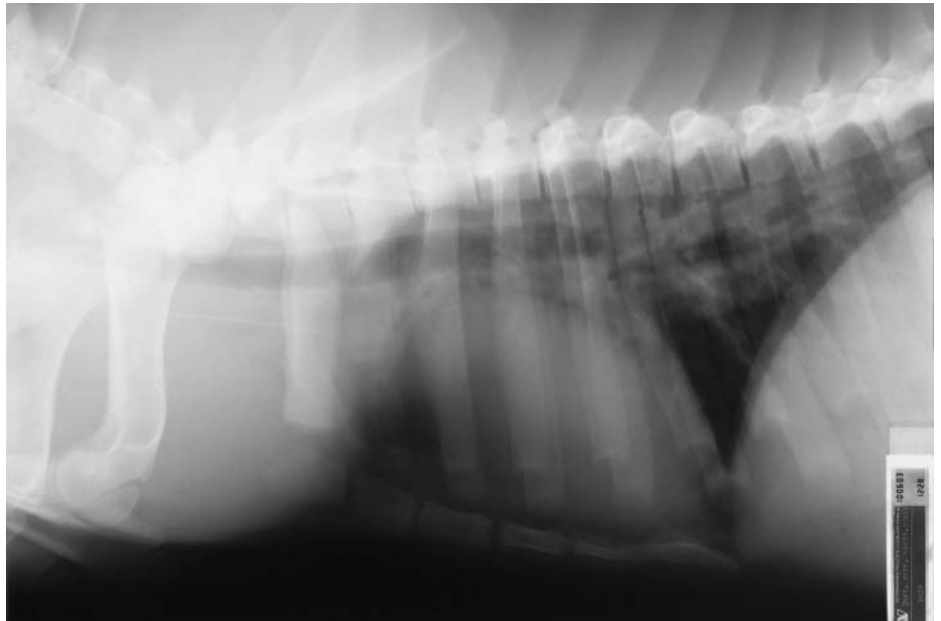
X-ray conformation of the intravenous catheter's position.
